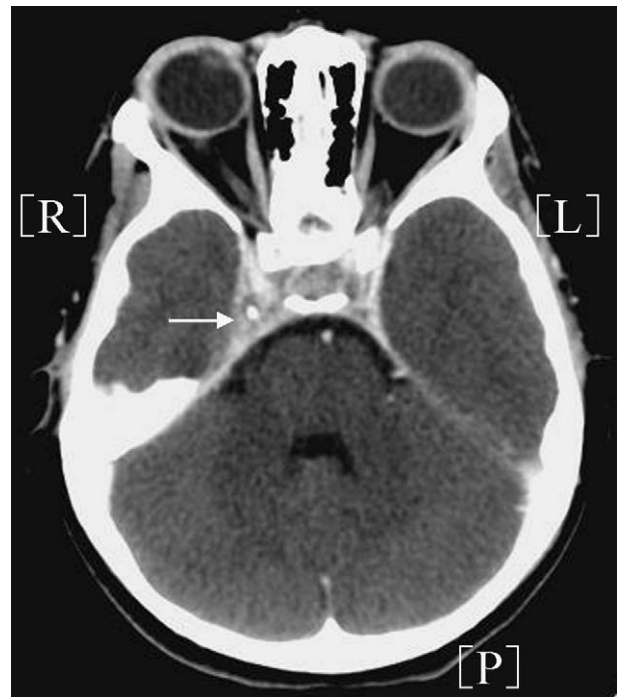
CT scan. Axial view. Thrombosis of the right cavernous sinus (thickening with a heterogenous aspect like a "comet-tail").
